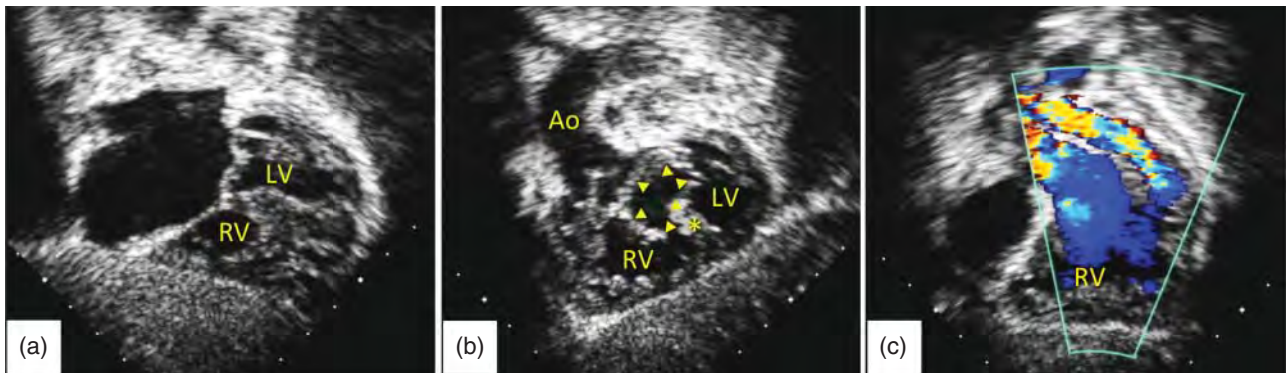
Echocardiography of a patient with tetralogy of Fallot with complete atrioventricular canal defect (“tet canal”). (a) Subcostal coronal (four-chamber) view showing a common atrioventricular valve with a large primum atrial septal defect. (b) Subcostal view in the plane of the atrioventricular valve (arrow heads). Interventricular septum is marked by asterisk (*). (c) Color Doppler image with slightly anterior tilt of transducer from (b). The laminar outflow from the right ventricle (RV) is through ventricular septal defect into the aorta (Ao). The turbulent flow is through the stenotic infundibulum into the main pulmonary artery. LV, left ventricle.
